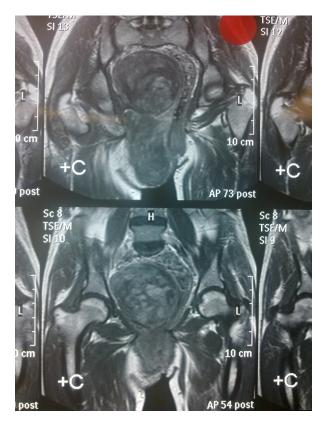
MRI of a 68 years' lady with AA tumor and rt. labial extension.
